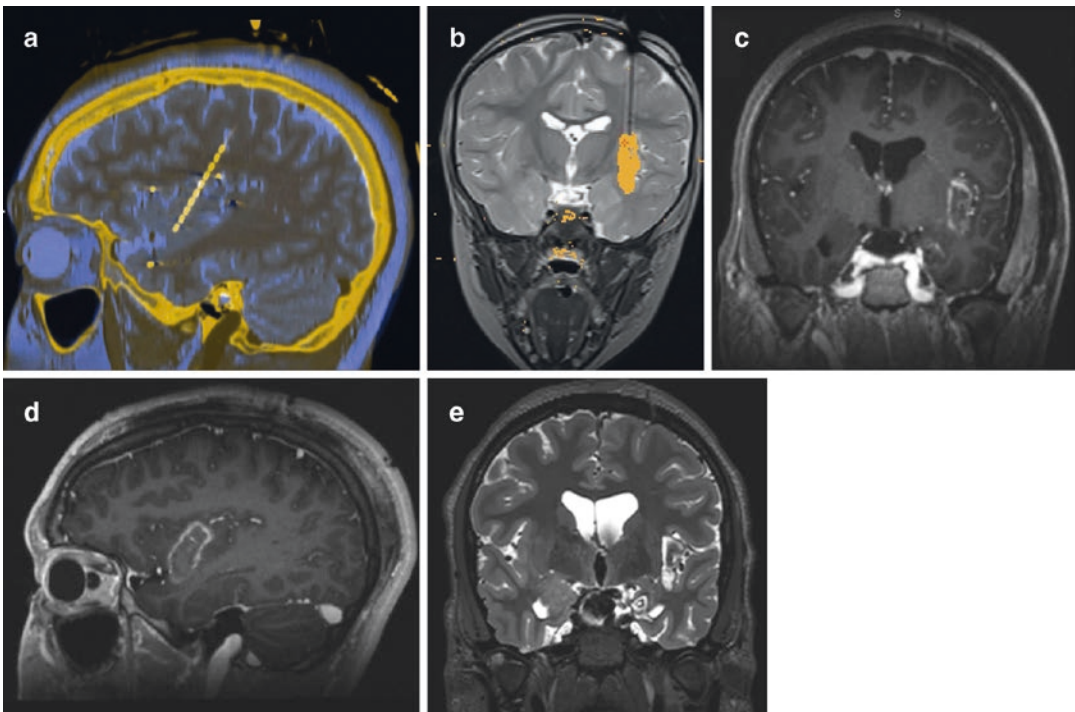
MRgLITT in pediatric insular epilepsy. (a) Sagittal view of a T2 MRI fused to a volumetric CT scan showing the placement of the depth electrode found to be the seizure onset zone by SEEG in a patient with insular epilepsy. (b) T2 coronal MRI with the superimposed TDE showing the estimated ablation along the middle short
